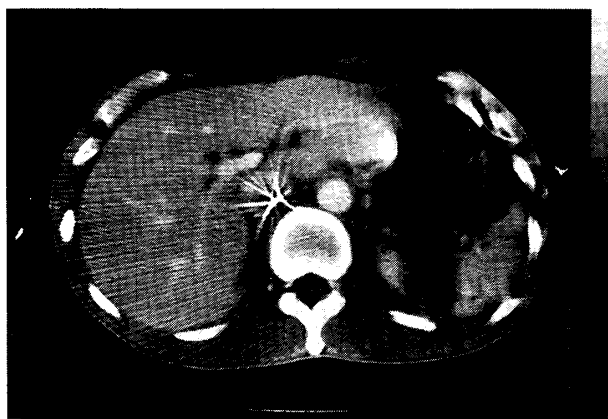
CT finding of patient No. 29 seemed to be a transection of the spleen (IIIb), but laparoscopic finding showed the absence of damage to the splenic surface (IIIa).
